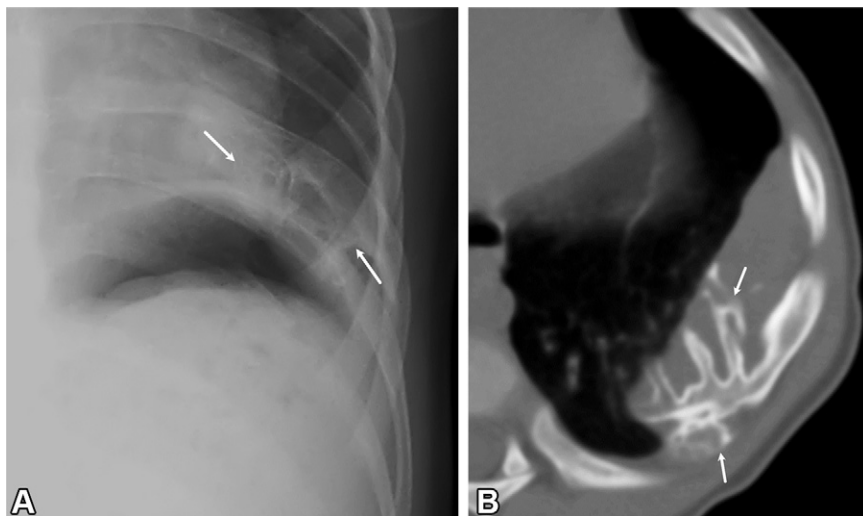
Mesenchymal hamartoma of the chest wall in a 1-year-old boy. (A) Frontal chest radiograph shows broadening and an irregular contour of the posterolateral left eighth rib associated with a large soft-tissue area of attenuation. Spurlike bone projections (arrows) arise from the inferior aspect of the eighth rib. (B) Axial CT image of the chest shows a large extrapleural mass associated with comblike bone projections stemming from the broad irregular eighth rib (arrows).
